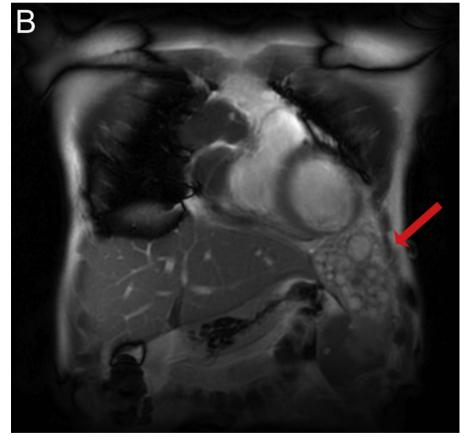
Magnetic resonance imaging with contrast enhancement with axial view (panel A) and coronal view (panel B) showing massive cystic cardiac echinococcosis.
